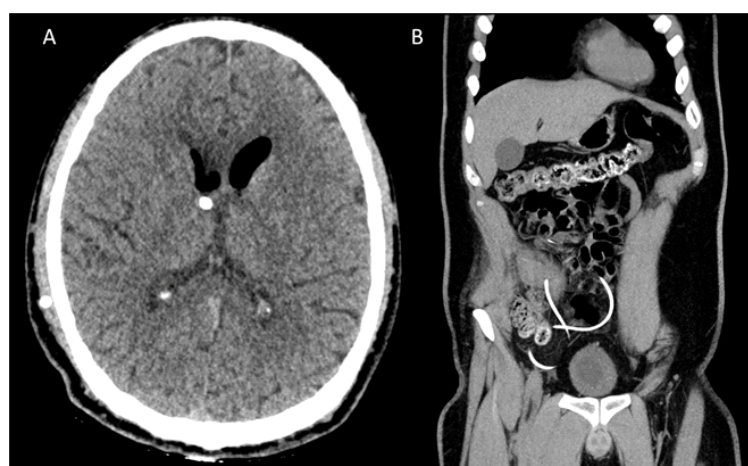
(A) Transaxial head CT with contrast enhancement showed ventricles on the axis, small in size, no longer dilated, with endoventricular air quotas in the frontal horns and presence of catheter at the distal end at the base of the right frontal horn. (B) Coronal whole body CT with contrast enhancement showed regularity of the abdominal organs and of the position of the distal peritoneal catheter in pelvis.
